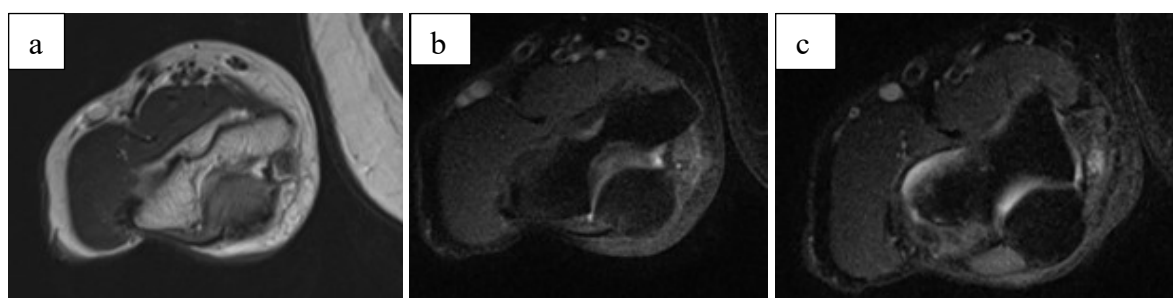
MRI images: axial T2W at CT (4a, 4b, 4c) and axial PDFS at CT (4d, 4e), coronal T1W (4f).
